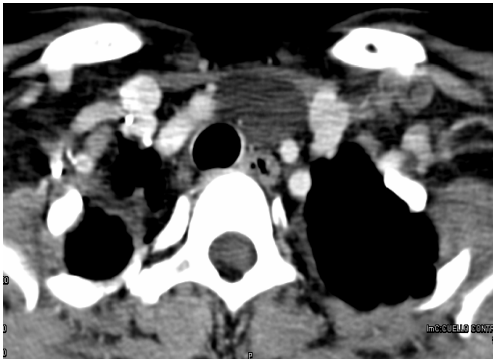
Contrast CT imaging of case 1.
